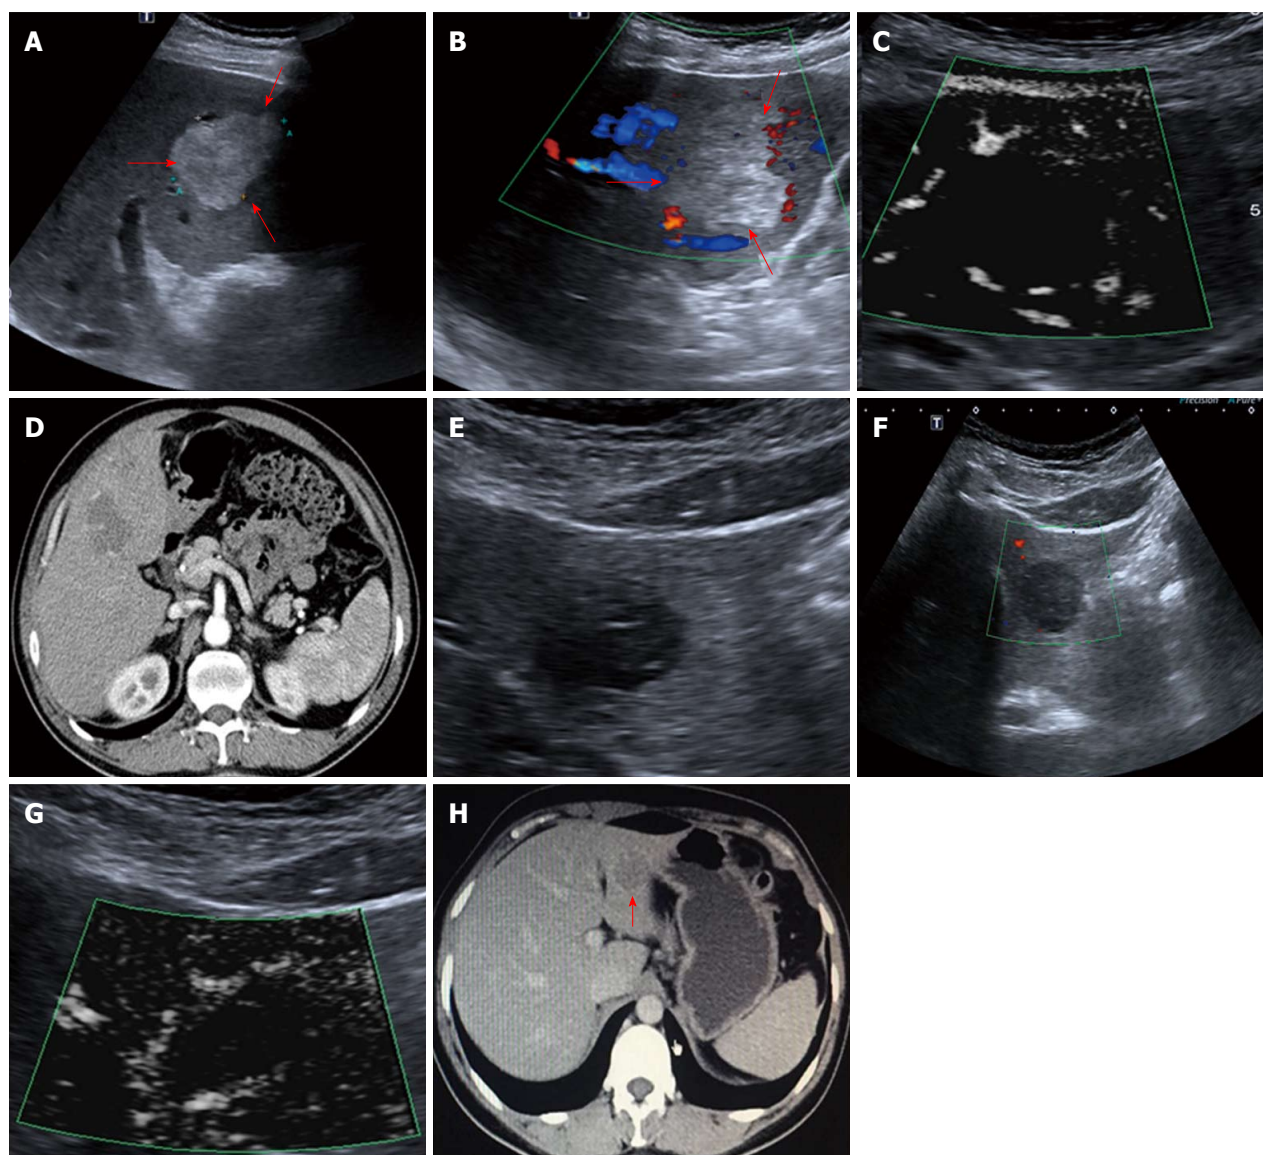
Strip rim type (type II). A-D: A 61-year-old male diagnosed with hemangioma. A: A high-echo lesion with a clear margin was evident in the left liver lobe; B: CDFI showed an interrupted strip blood flow signal around the edge of this lesion; C: SMI showed a relatively continuous strip rim-distributed microvascular structure; D: Contrast-enhanced CT showed strip rim enhancement of the lesion in the arterial phase. E-H: A 63-year-old male diagnosed with hemangioma. E: A low-echo lesion with a clear margin was evident in the left liver lobe; F: CDFI showed no blood flow signal for this lesion; G: SMI showed a continuous strip rim microvascular structure; H: Contrast-enhanced CT showed strip rim enhancement of the lesion in the arterial phase. SMI: Superb microvascular imaging.
